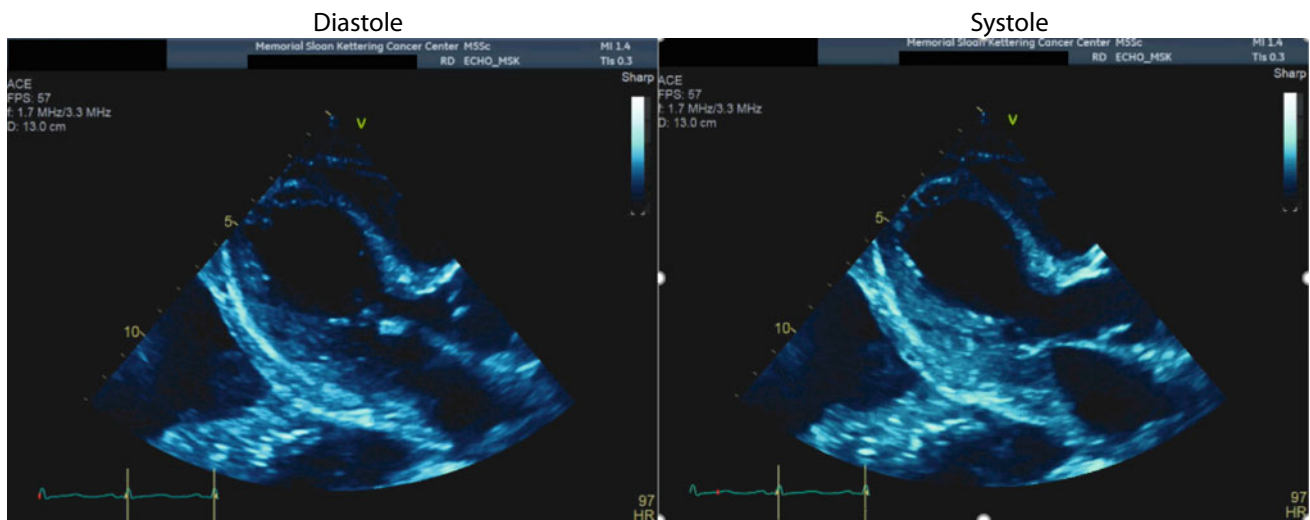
Echocardiographic images in diastole and systole acquired while the patient experienced grade 4 CRS showing marked deterioration in systolic ventricular function compared with baseline
